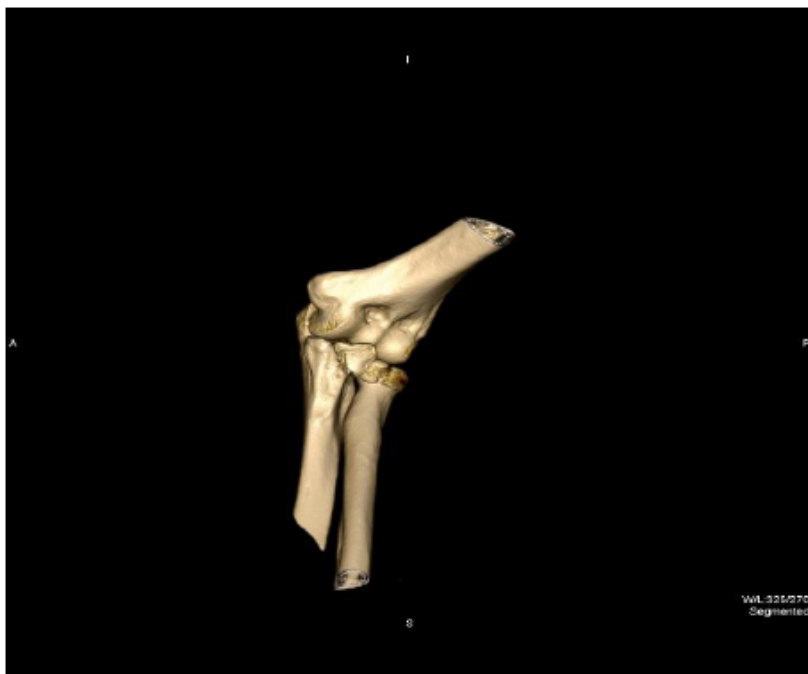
CT image showing a fracture of less than 50% of the coronoid. Fracture of the head of the radio with minimum displacement of the fragments.
